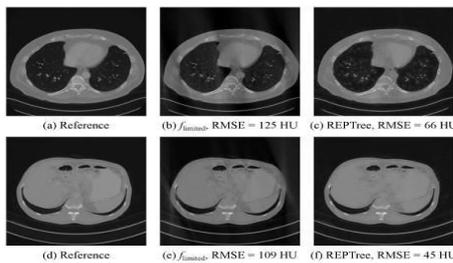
The reference images, the 160° limited angle reconstructions (f_{\minima}), and the machine learning results using REPTree of the low-dose CT data in parallel-beam geometry. Window: [-1150, 1300] HU.
